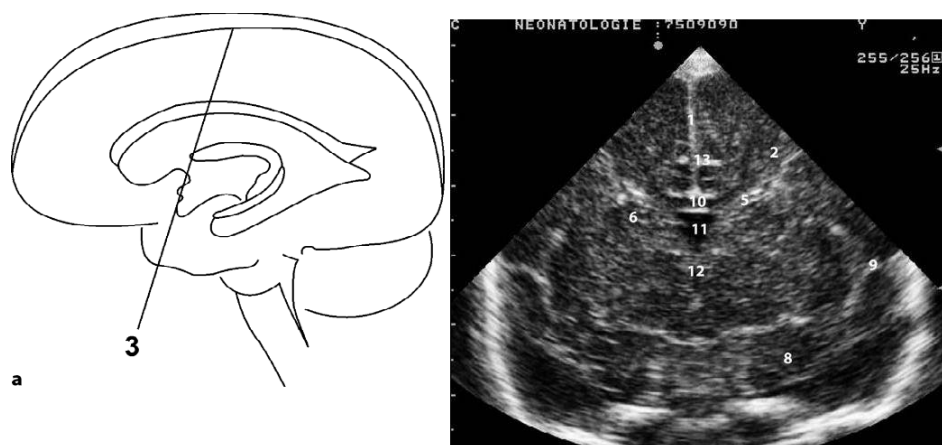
show a Third coronal plane (C3) at the level of the foramen of Monro and the third ventricle. b Ultrasound scan of the third coronal plane (C3) at the level of the foramen of Monro and the third ventricle
